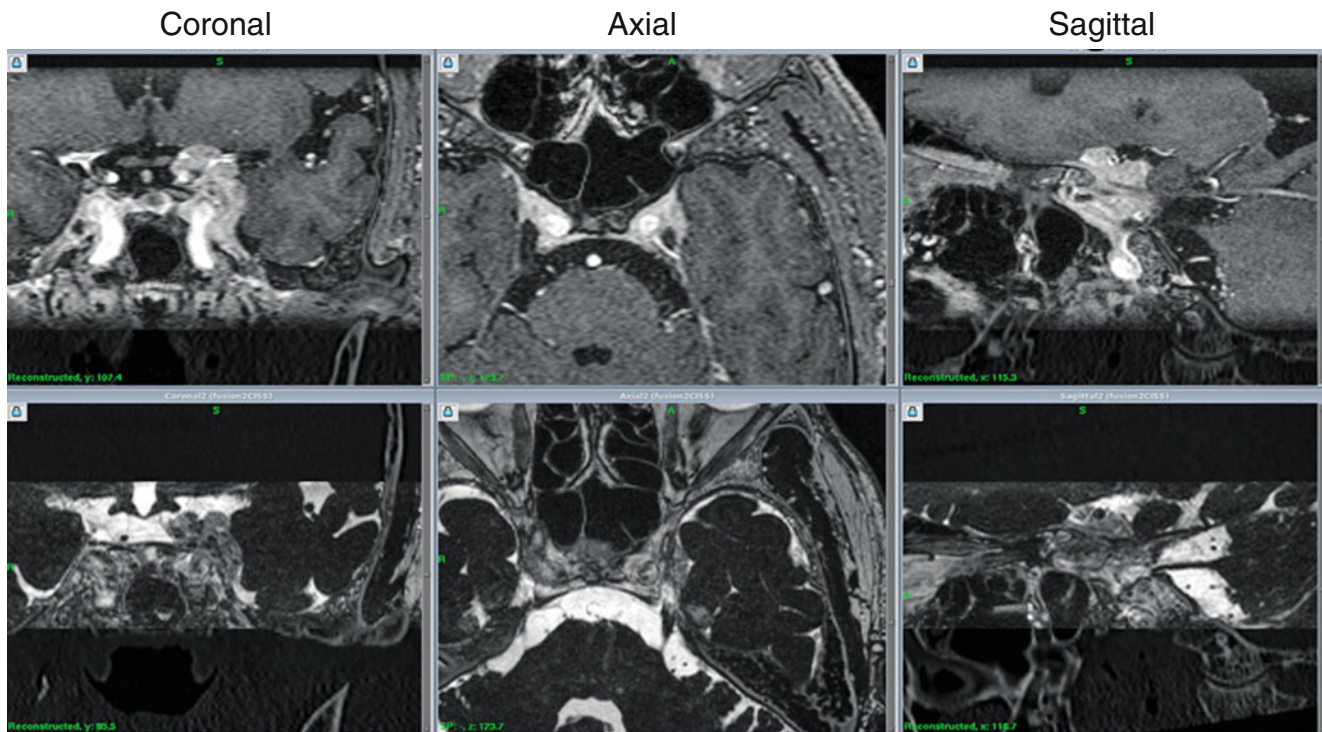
Gadolinium-enhanced multiplanar reconstructed (MPR) magnetic resonance (MR) images (*upper row*) and constructive interference in steady state (CISS) MR images (*lower row*) of a left cavernous sinus
